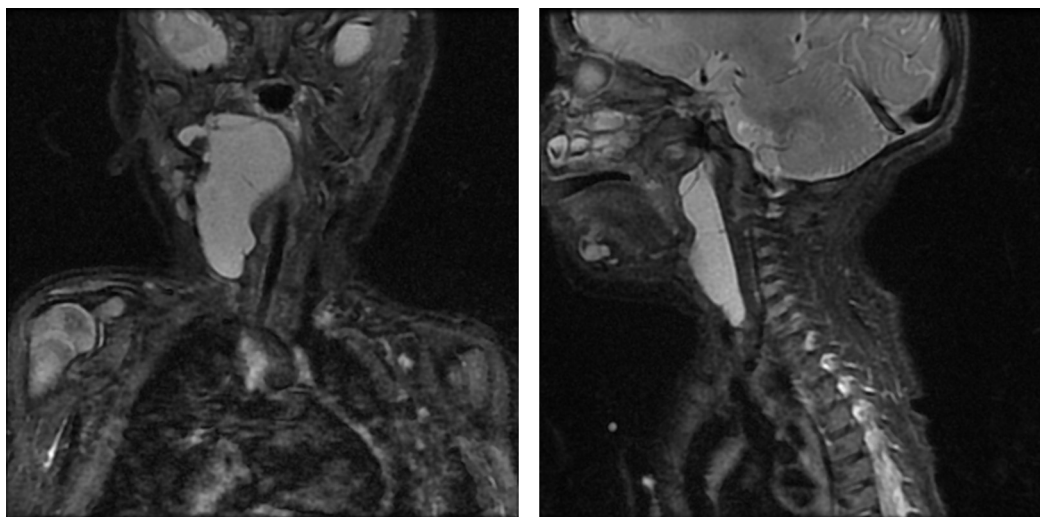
Pre-treatment MRI of the neck.
